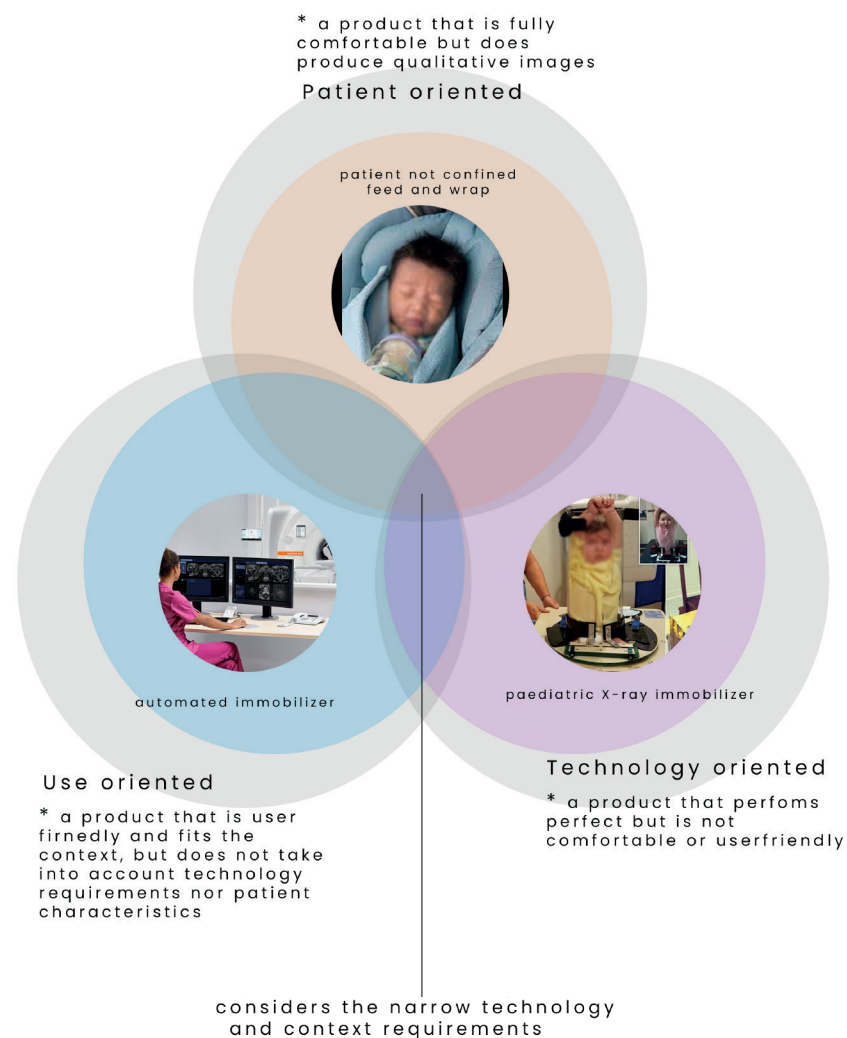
Solution direction of a non sedative MRI
